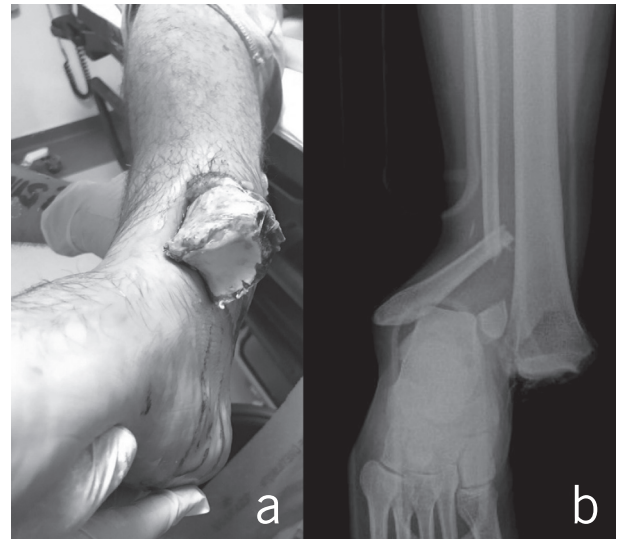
Pronation-external rotation open ankle fractures are typically medial in nature, located over the malleolus, and accompanied by a horizontal skin laceration (a). Anteroposterior radiograph of the fracture (b).
